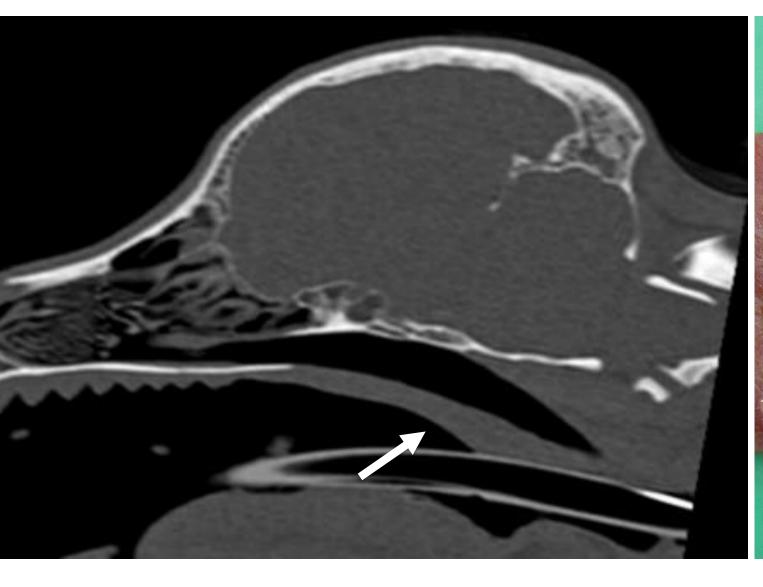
CT scan. Abnormal nasopharynx with absence of communication between nasopharynx and oropharynx due to abnormally long palatopharyngeal muscles in continuity with the oesophagus (arrow).
